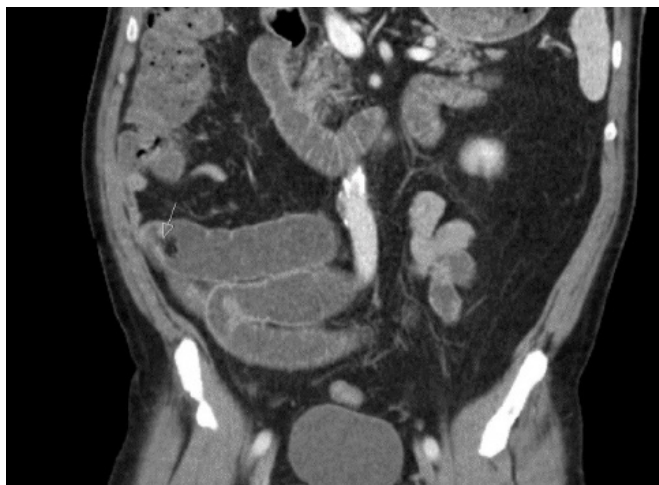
Coronal CT scan. Published with Permission
